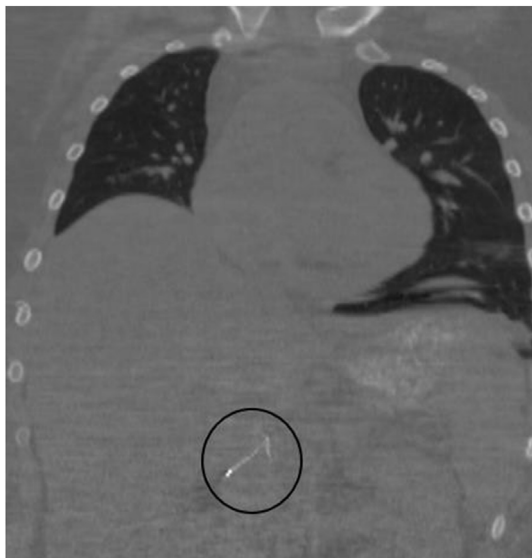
Coronal CT view shows the lower struts in the inferior vena cava (black circle).
